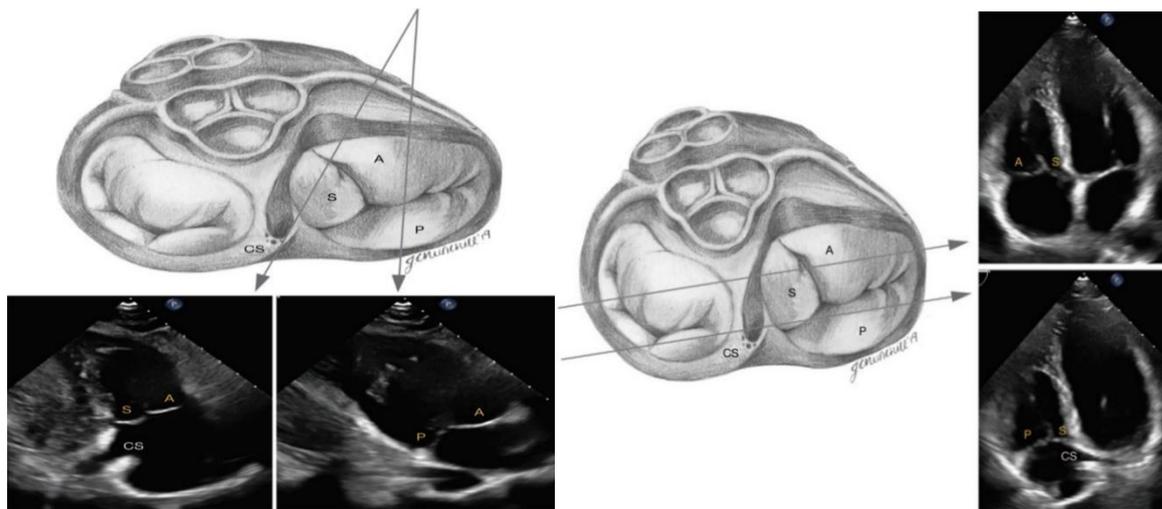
Modified parasternal long axis view (Left) & A4C view (Right) (16)
